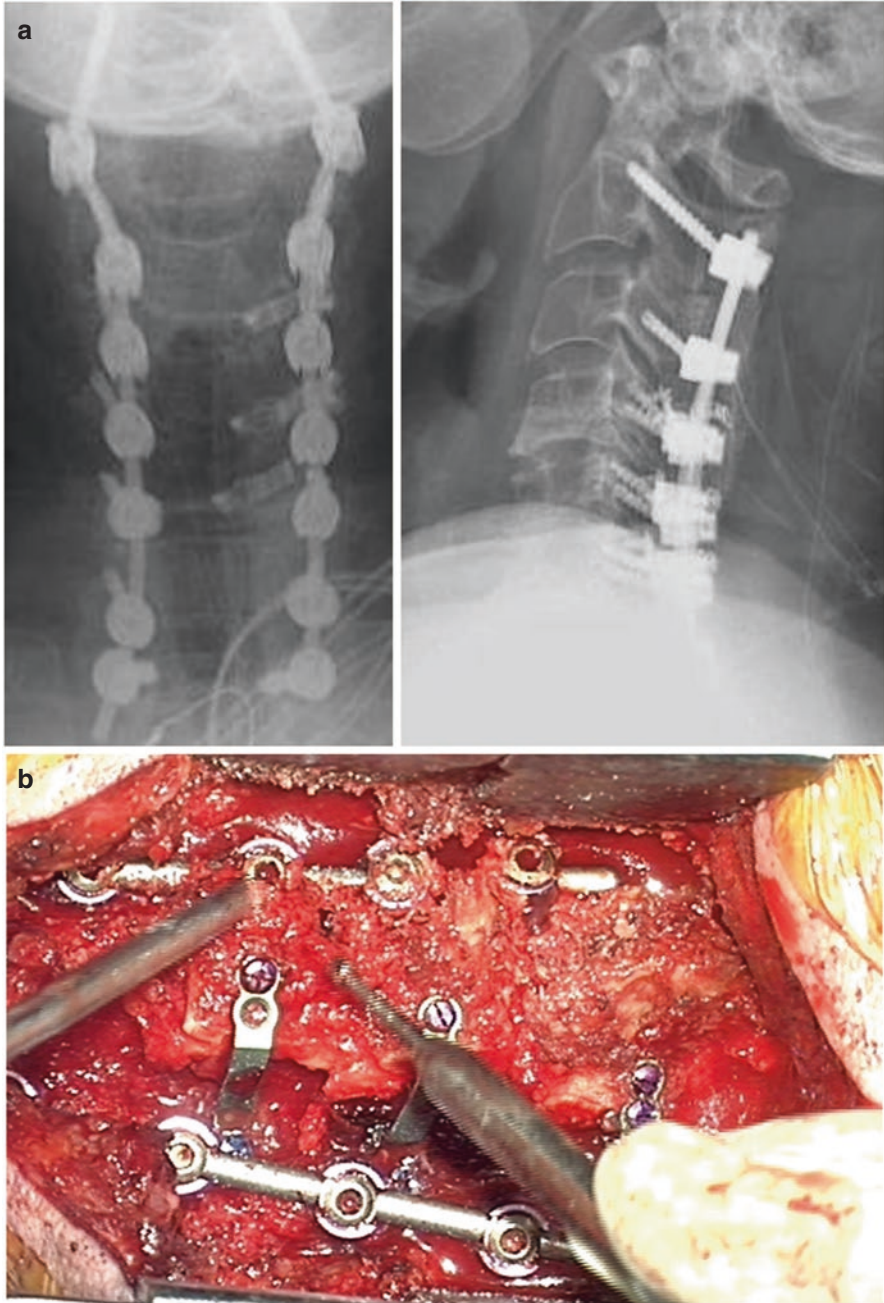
(a) Radiograph images and (b) intraoperative depiction of how mini-laminoplasty plates can be used without fixation screws to prop up the laminae or the holes can be enlarged with a burr and the lateral mass screws can be placed thru the hole
